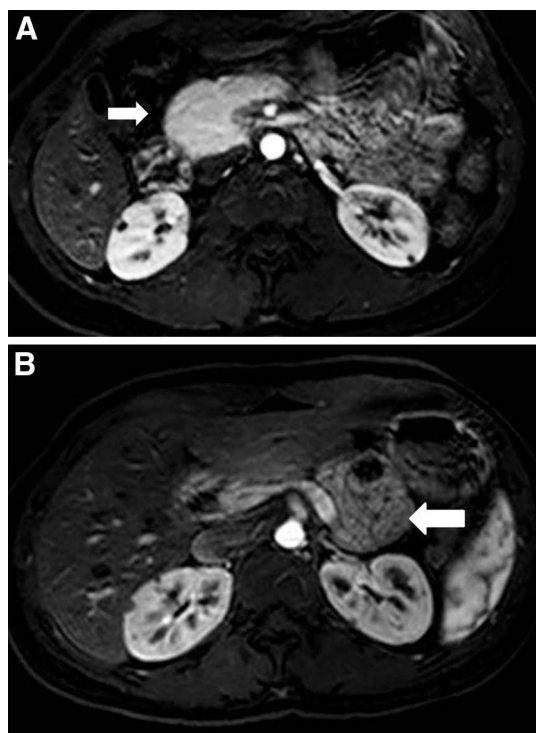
Pancreatic hypoplasia. a Axial gadolinium-enhanced MR image shows truncated dorsal pancreas or partial agenesis of the pancreas with pseudotumoral enlargement of pancreatic head and uncinate (*arrow*). b Axial gadolinium-enhanced MR image at a different level shows absence of pancreatic neck, body and tail ventral to splenic vein with small bowel extending into this potential area (dependent intestine sign) (*arrow*)
